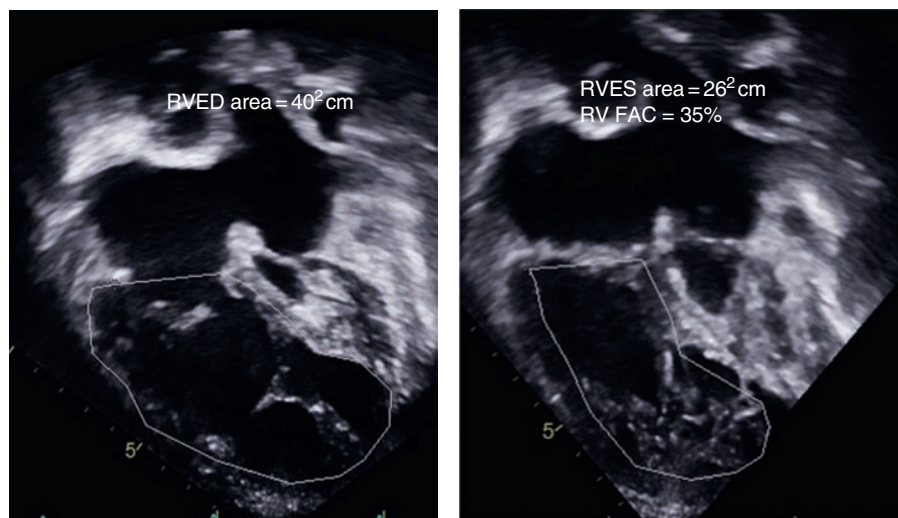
Quantification of single ventricular function. From an apical four-chamber view, fractional area change (FAC) can be measured by tracing the end-diastolic (RVED) and end-systolic (RVES) area and calculating the FAC, which in this patient was 35%.
